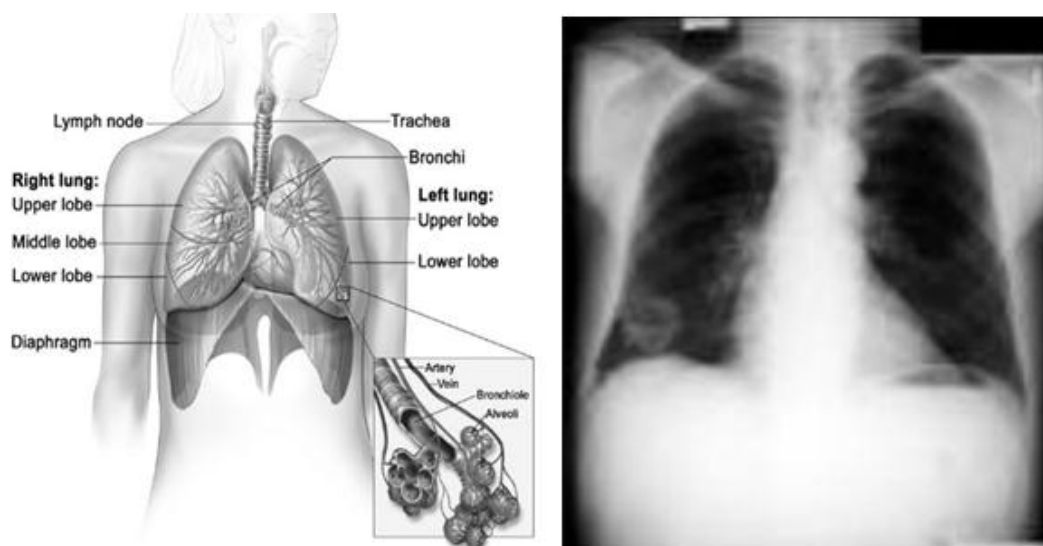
Anatomy of the respiratory system, showing the trachea and both lungs and their lobes and airways. Lymph nodes and the diaphragm are also shown. Oxygen is inhaled into the lungs and passes through the thin membranes of the alveoli and, into the bloodstream. And an x-ray image for diagnostic purposes.^[35,36,42]
